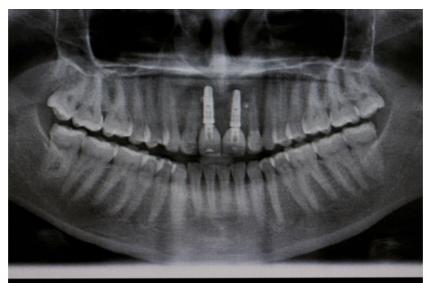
Panaromic radiograph 1 year later
